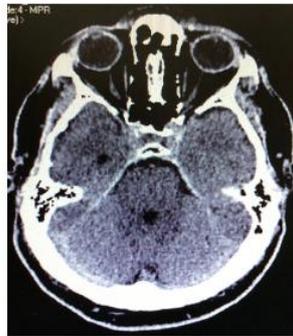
CT scan of the head
